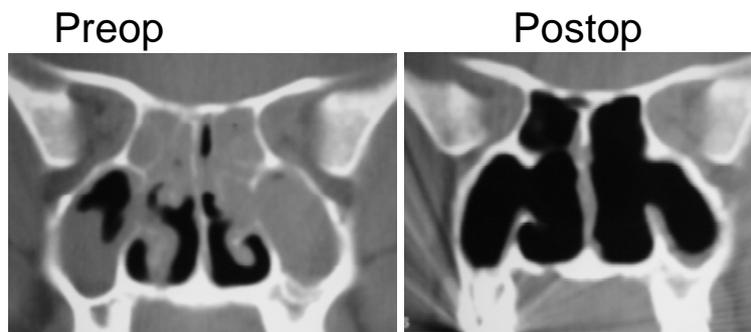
(b):coronal CT (Posterior section) showing removal of posterior end of IT and extended MMA
